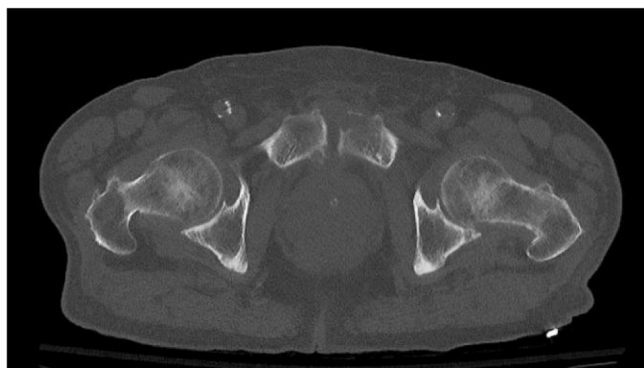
Osteolytic lesion of the cortical of the anteromedial part of the left pubic symphysis in the initial CT-scanner.
